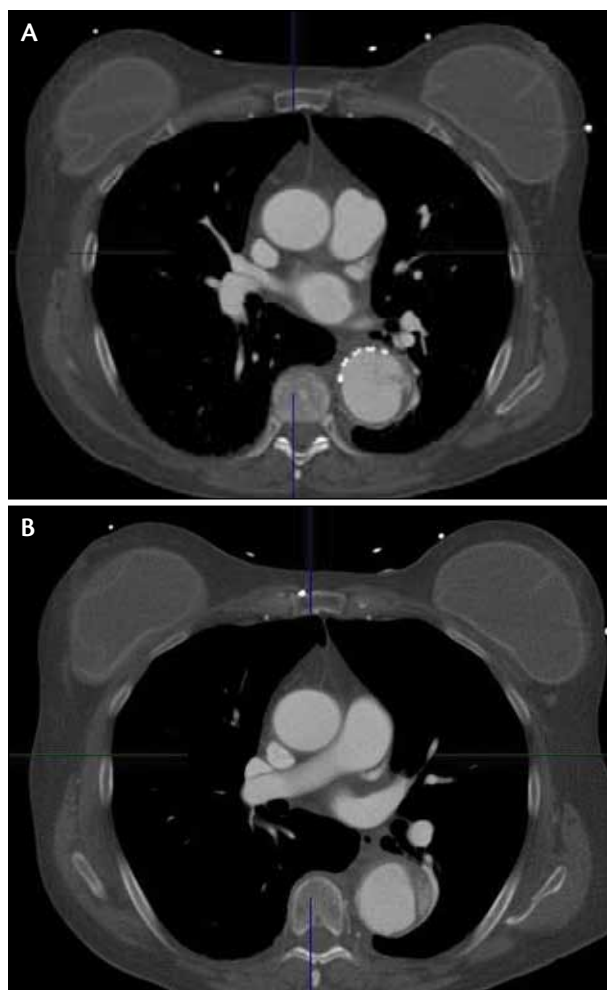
CT scan showing an aortic dissection with the entry tear at the level of the proximal stent of the endograft (A) and retrograde flow in the false lumen (B).
